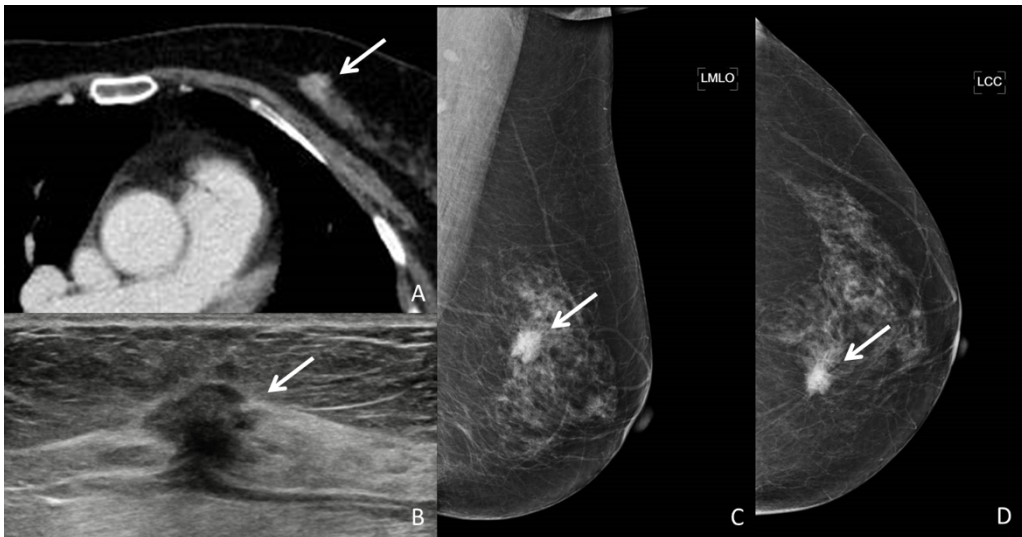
A 62-year-old woman with invasive ductal carcinoma of the left breast. She presented with chronic cough and dyspnea and chest CT was performed for evaluation of interstitial lung disease. A: Contrast-enhanced chest CT shows an irregular shape mass with a spiculated margin and heterogeneous enhancement at upper-inner quadrant of left breast. B: Ultrasound of the same lesion shows an irregular hypoechoic mass. C and D: Mammography images of the same lesion show a spiculated mass at upper-inner quadrant of left breast.
